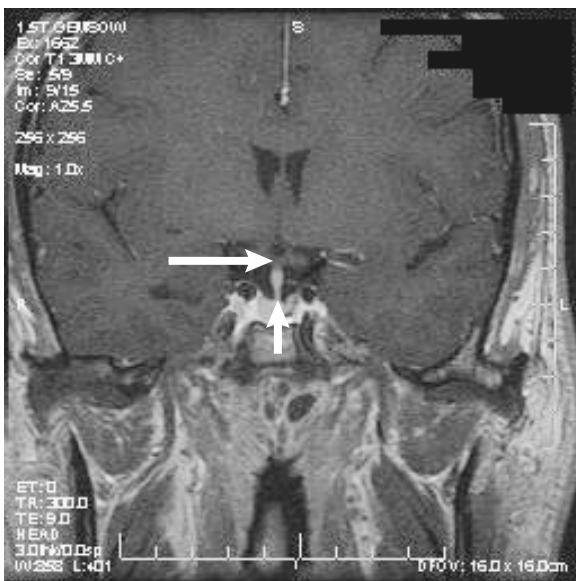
Pituitary stalk (short arrow) in relation to the optic chiasm (long arrow) as seen on magnetic resonance imaging (coronal section).
